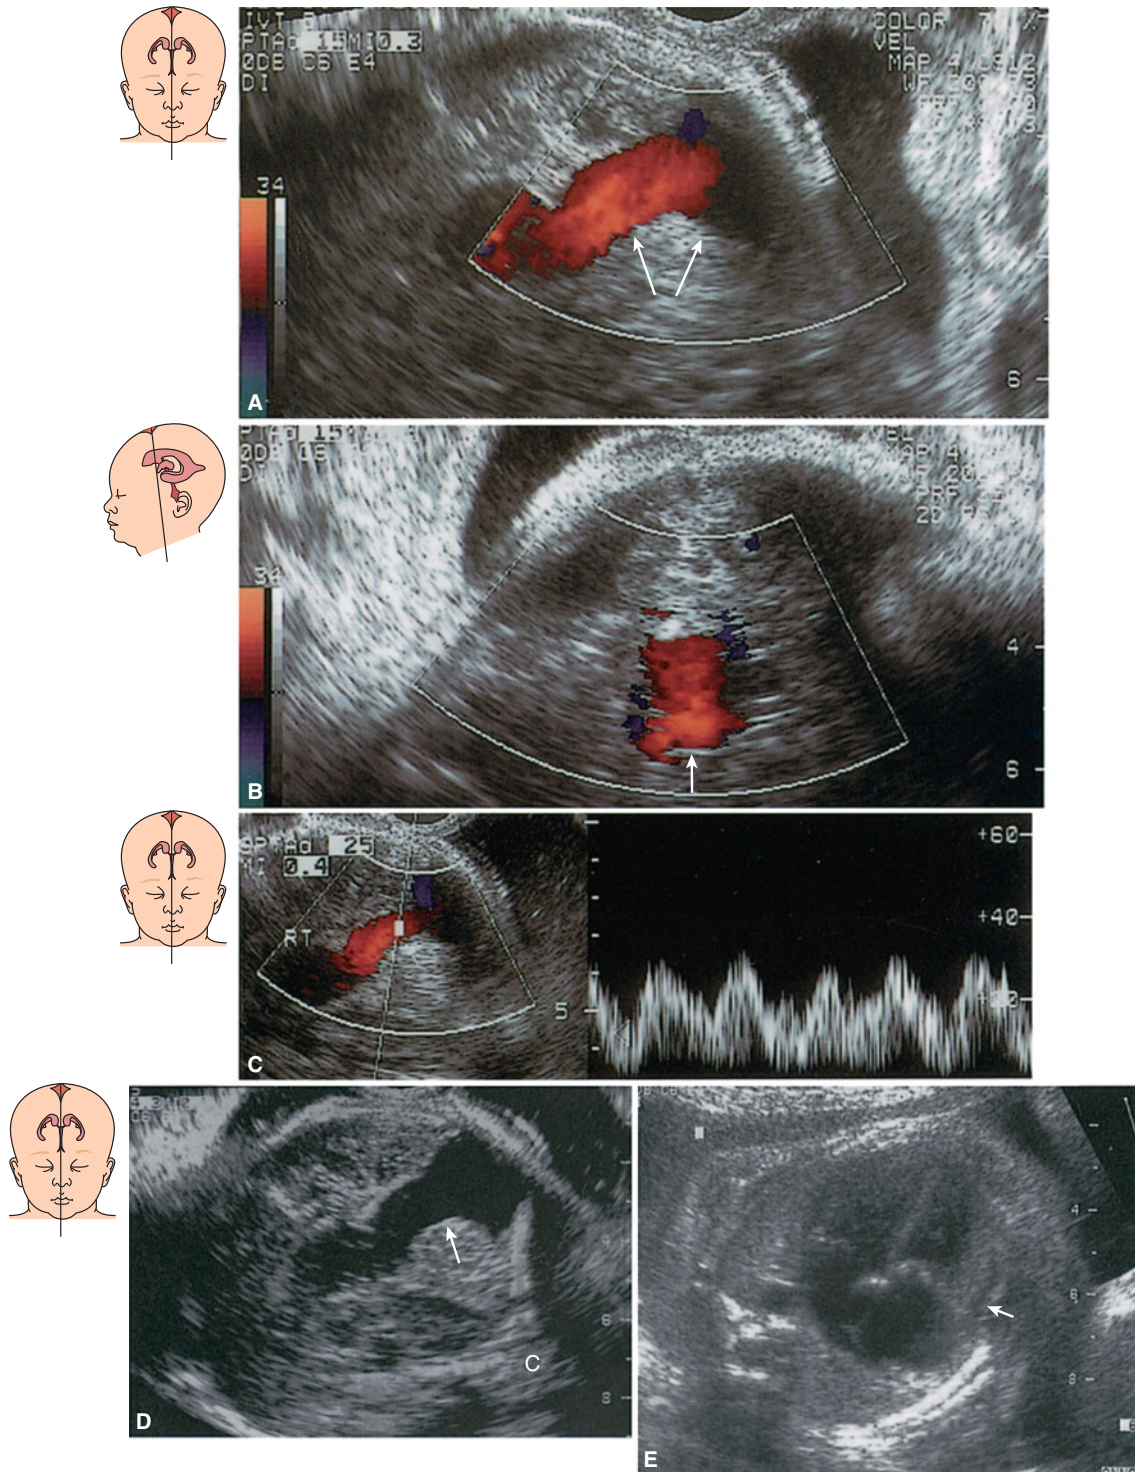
Aneurysm of the vein of Galen at 33 postmenstrual weeks. A–C. C-coded Doppler images of the lesion (arrows). (A) The median plane. (B) The midcoronal-1 plane. (C) In the median plane, note the wide (~1.2 cm) structure above the cerebellum (C) with flow toward the posterior pole of the brain. The Doppler evaluation showed a pulsating venous flow. (D) Grayscale image in the median plane. (E) Four-chamber view of the heart showing relative cardiomegaly; heart-to-chest diameter ratio: 0.65 (normal 0.45–0.5) and a very small amount of pericardial effusion (arrow). There was no atrio-ventricular valve regurgitation, but the heart had hyperdynamic motion consistent with a cerebral arteriovenous malformation. There was no dilation of the vessels in the neck of the fetus. Three attempts at embolization were performed after the delivery, but the neonate died during the last such attempt.
